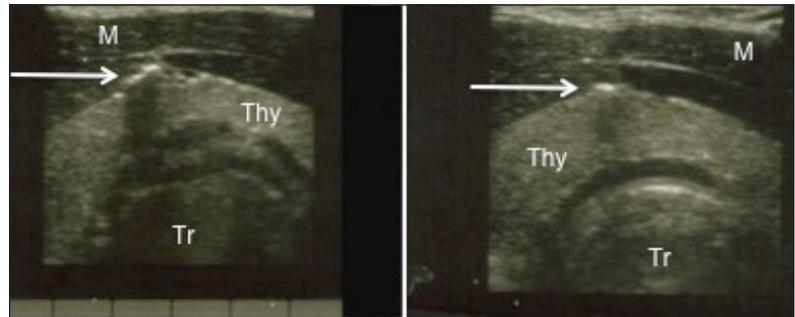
Ultrasound of the neck. The white arrow indicates free air with posterior acoustic shadowing in the soft tissue of the neck. Free air is identified by the hyperechoic white spots. The white "M" indicates sternohyoid and sternothyroid muscles. The white "Thy" indicates the thyroid. The white "Tr" indicates the trachea.
